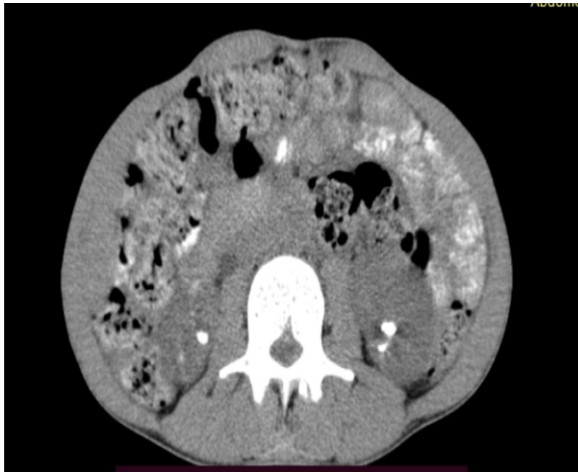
Abdominal CT showing bilateral renal stones
